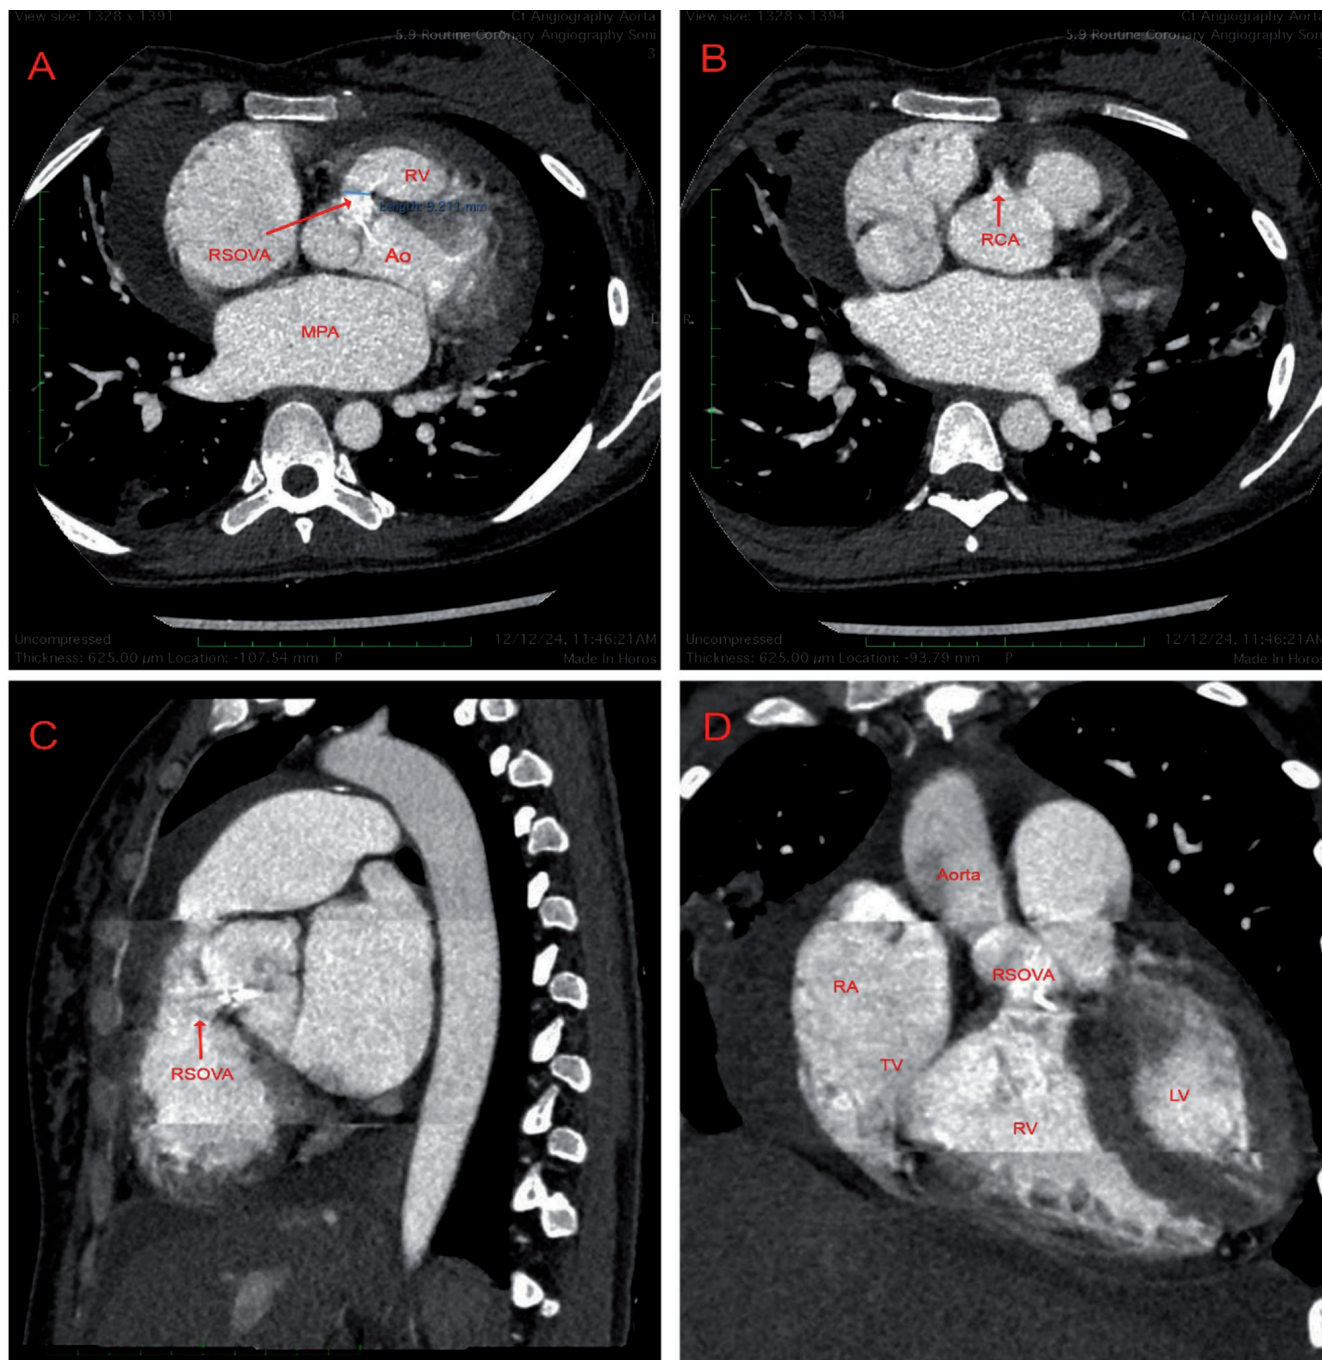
Computed tomography angiogram images. A) Axial section showing ruptured sinus of Valsalva aneurysm (RSOVA), measuring 9.2 mm arising from right coronary cusp communicating with the right ventricle (RV); B) main pulmonary artery (MPA) is mildly dilated; C) axial section showing origin of right coronary artery (RCA), confirming the rupture in right coronary cusp; D) sagittal and coronal sections delineating the site of rupture. Mild pericardial effusion was also noted. RA, right atrium; LV, left ventricle; Ao, aorta; TV, tricuspid valve.
